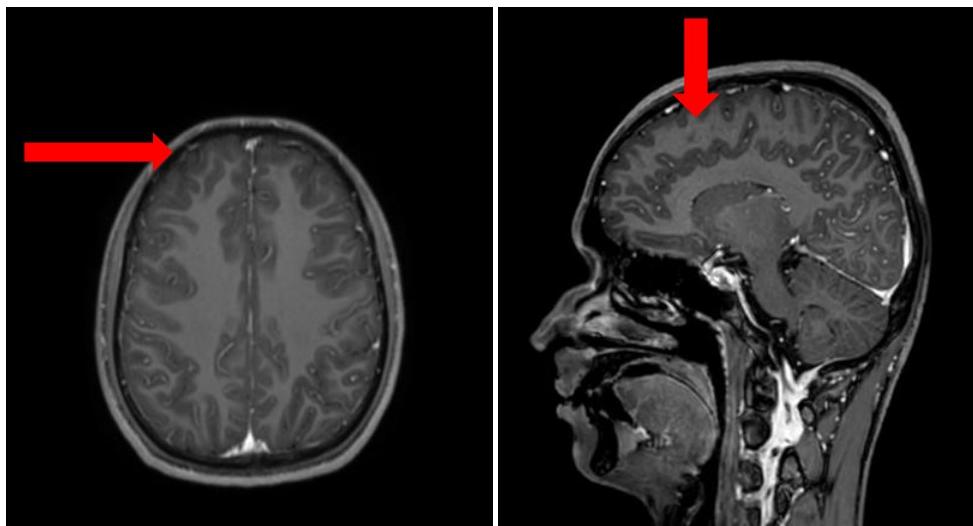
MRI brain and contrast study which revealed meningeal enhancement
